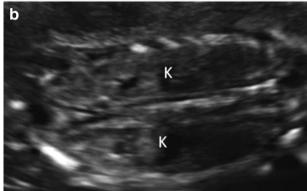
a Transverse scan of kidneys. SP spine; K kidney b Coronal sonogram of the fetal kidneys. K kidneys
